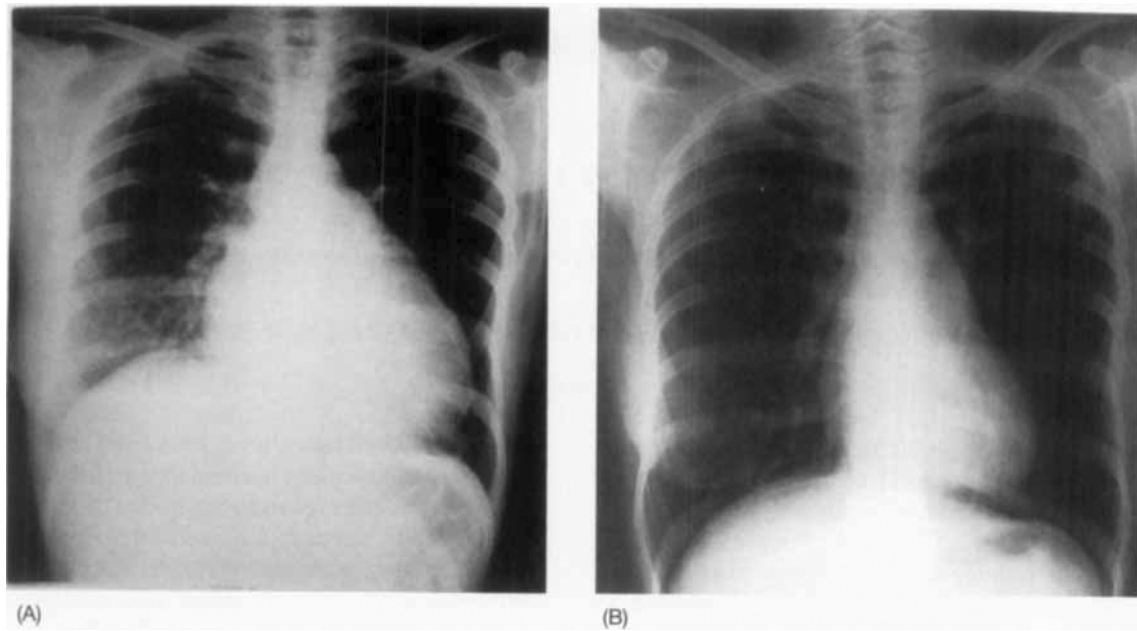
Chest x-ray images before (A) and after carvedilol therapy (B).
